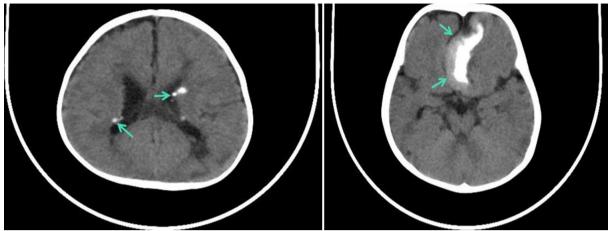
CT Brain (plain axial) - A and B
